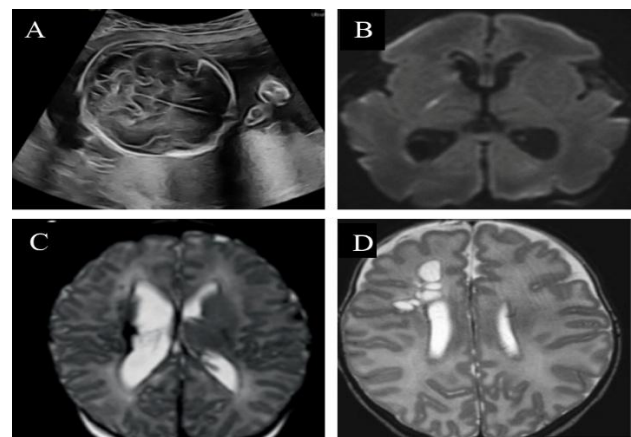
(A) Neurosonography with irregular contours and dilation of the ventricles, probable hemorrhage, and hydrocephalus; (B) brain MRI of a premature infant; (C) HIV, diffusion restriction in the midportion of the posterior limb of the internal capsule (PLIC); and (D) MRI of a premature infant shows hemorrhage with a multicystic pattern on the T2-weighted sequence.
